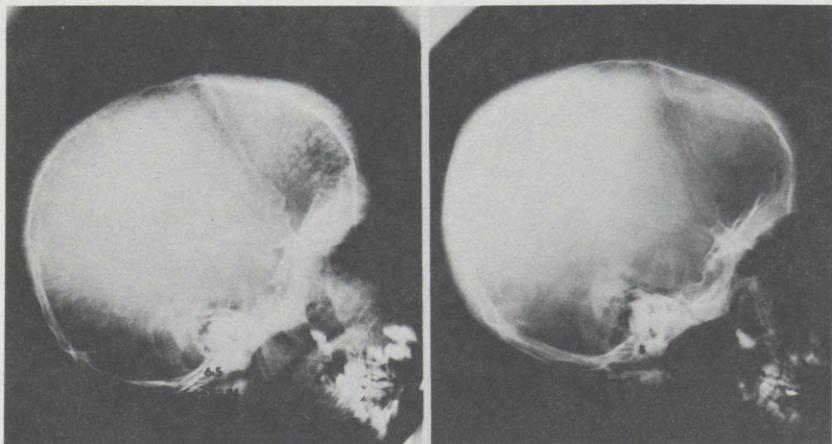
Roentgenograms of the skull of a patient with homozygous beta thalassemia at the age of 6½ years (left), before splenectomy and transfusion therapy, and at the age of 8 (right) after splenectomy and transfusion therapy.
